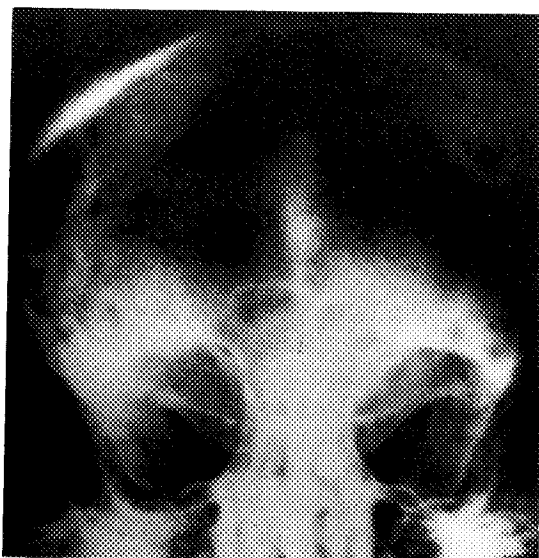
Skull radiograph showing osteosclerotic changes in the fronto-orbital regions and fronto-ethmoidal sinuses, as well as osteolytic areas in the frontobasal and parietal regions.
